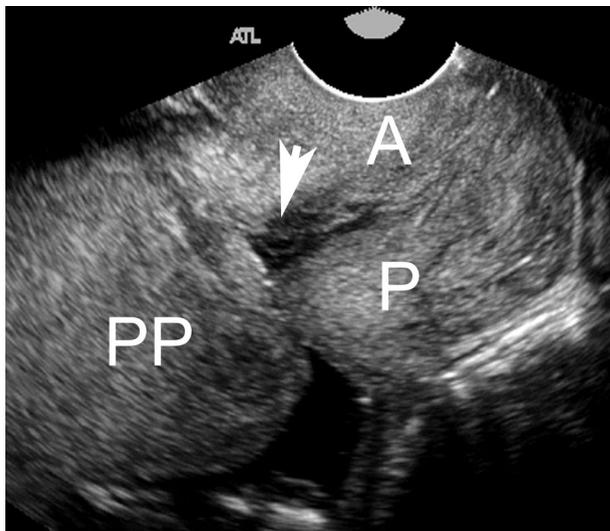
Transvaginal sonogram of a complete placenta previa (PP). Note that both the placenta and the internal cervical os (arrow) are clearly depicted. A, anterior lip of cervix; P, posterior lip of cervix. The placenta just overlaps the internal os. One can see how this could become a partial placenta previa covering just the anterior lip of the cervix if cervical dilation were to occur.
